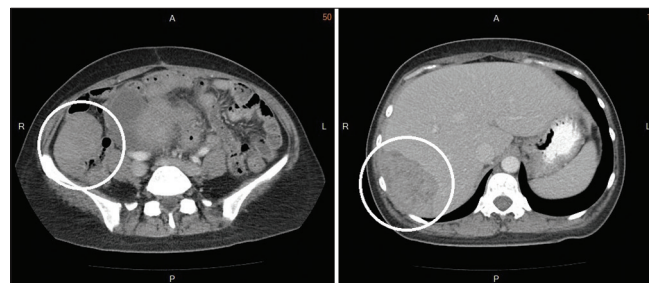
A 8.6 cm × 8.5 cm × 5.1 cm heterogeneous mass occupying the right hepatic lobe (left) and 7.1 cm × 8.0 cm × 4.1 cm heterogeneous mass over right lower abdomen attached to the ascending colon (right) are visible on computed tomography. These features resemble those of intra-abdominal abscess or metastatic tumors
